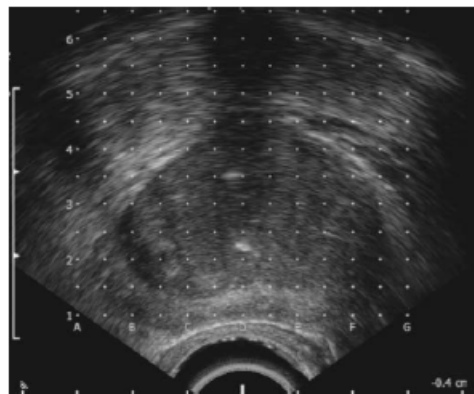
Ultrasound image of the treatment area for a prostate cancer patient [86].
